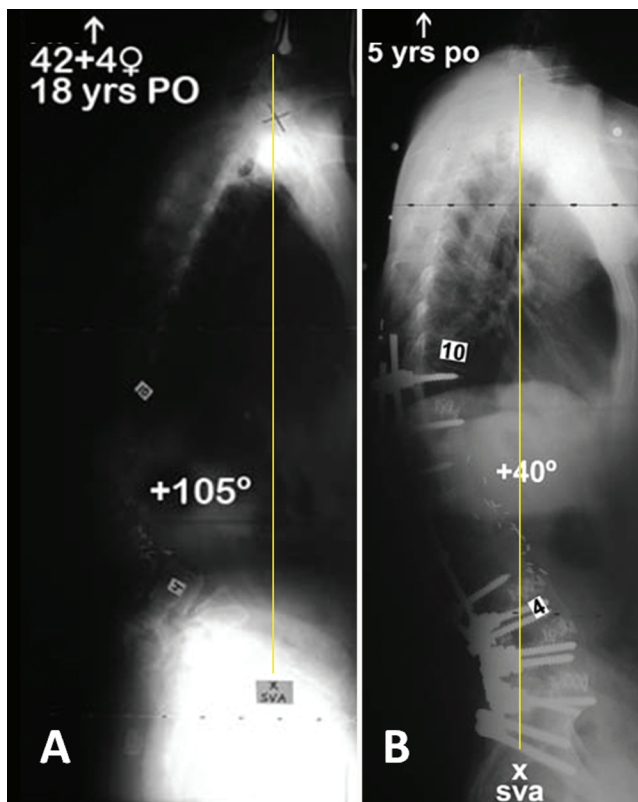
Case 2. Preoperative (that is, before the SPO; A) and post-operative (B) lateral standing 36-inch plain radiographs. Note improvement in sagittal balance as evident by C-7 plumbline (yellow line). sva = sagittal vertical alignment.
